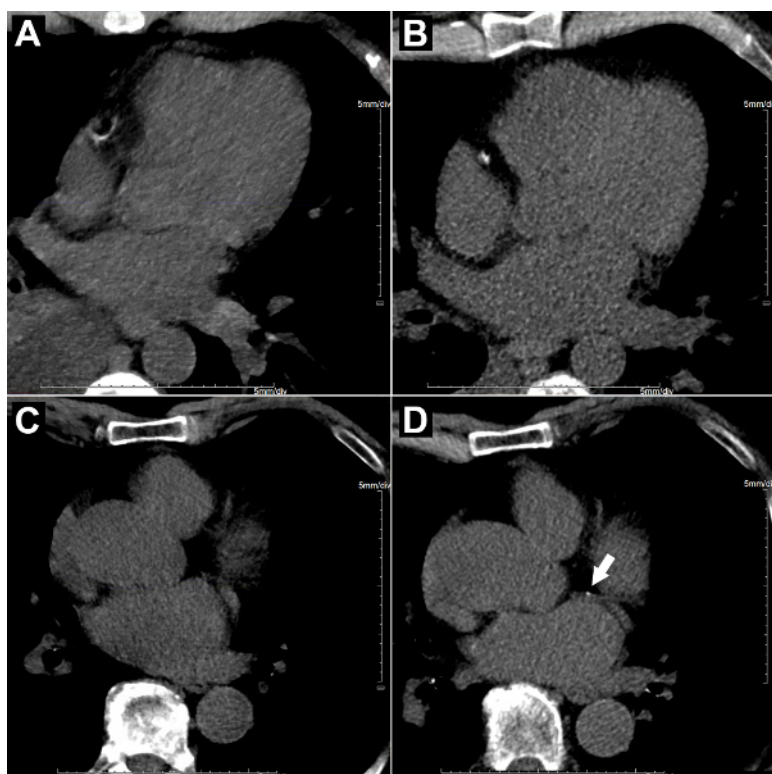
The impact of gating on the visualization of coronary calcium. The upper two panels show (A) a non-gated and (B) a gated CT chest scan on the same patient, where calcification in the right coronary artery (RCA) is still visualized. The lower two panels show (C) a non-gated and (D) a gated CT chest scan on a different patient showing cardiac motion obscuring the mild coronary calcification in the proximal left circumflex artery (white arrow). [Please click here to view a larger version of this figure.](#)
